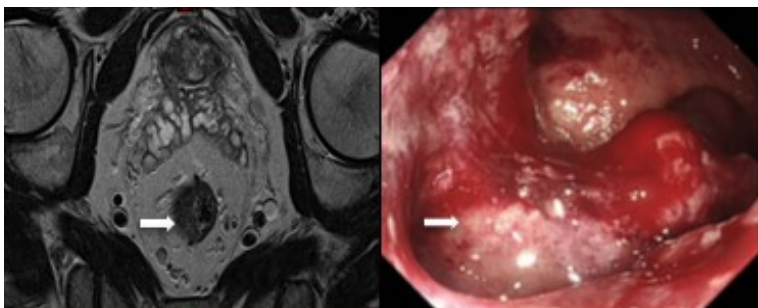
Week 12 MRI pelvis and endoscopy showing complete response. Scar indicated by black arrow
